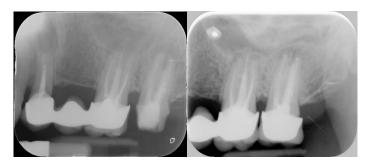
Pre-operative intraoral X-rays.*
